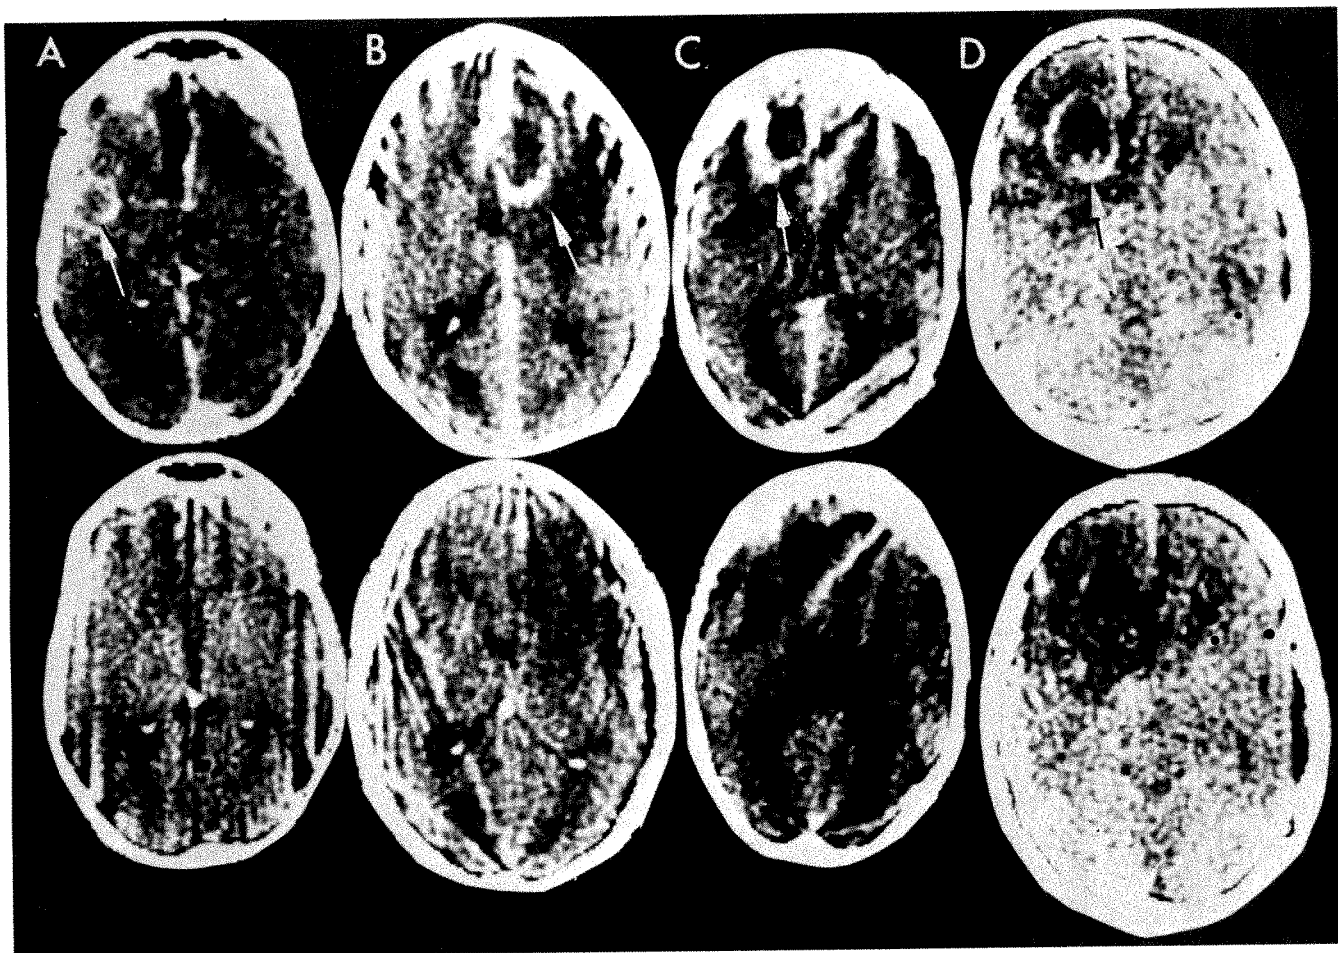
Four cases showing ringlike enhancement. CT scans after 300 ml meglumine diatrizoate (*upper*) and without contrast (*lower*). A, Proven infarction at surgery; preoperative diagnosis, abscess. B, Surgically proven right frontal glioblastoma. C, Surgically proven left frontal abscess. D, Left frontal undifferentiated lung metastasis.
